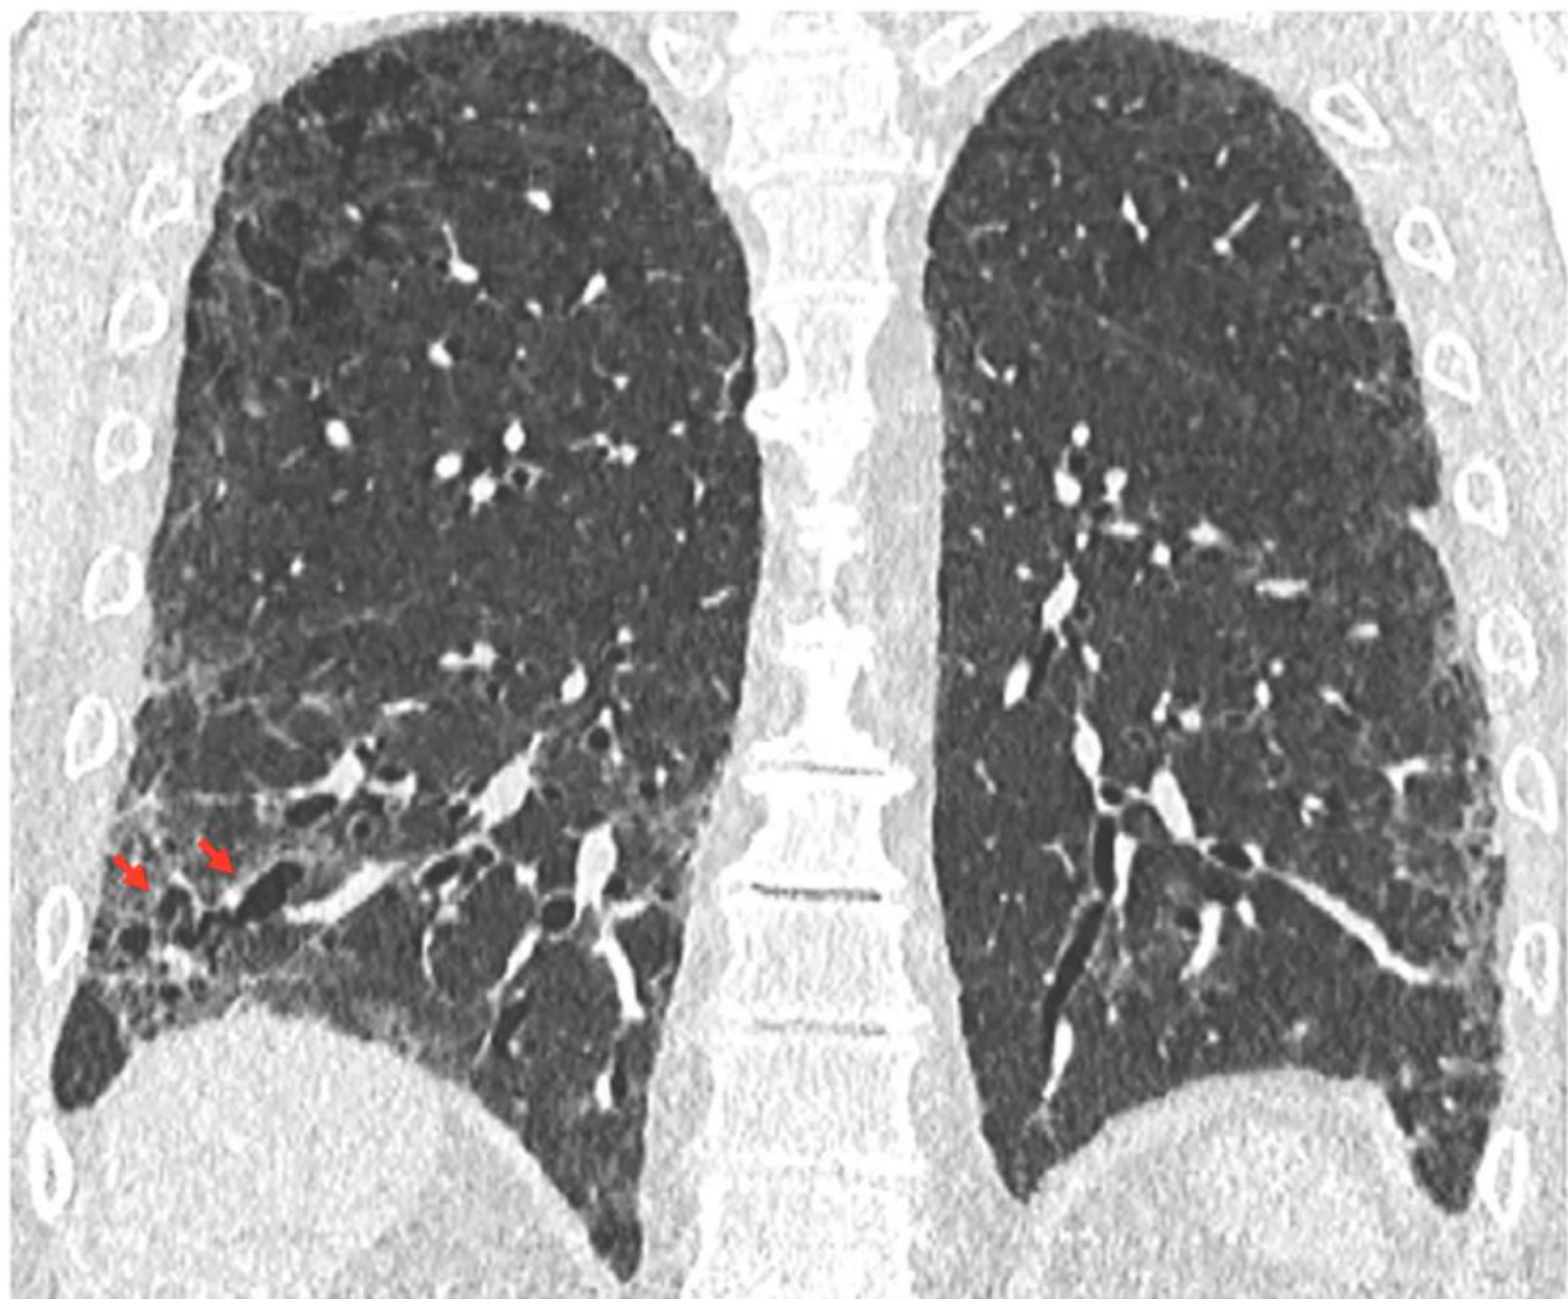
Traction bronchiectasis/bronchiolectasis. Axial, sagittal, and coronal computed tomography images show subpleural-predominant, lower lung-predominant reticular abnormality with traction bronchiectasis (arrows). Traction bronchiectasis/bronchiolectasis represents irregular bronchial and/or bronchiolar dilatation caused by surrounding retractile fibrosis; distorted airways are thus identified in a background of reticulation and/or ground-glass attenuation. On contiguous high-resolution computed tomography sections, the dilated bronchi or bronchioles can be tracked back toward more central bronchi. The pattern in this patient represents the probable usual interstitial pneumonia pattern.
